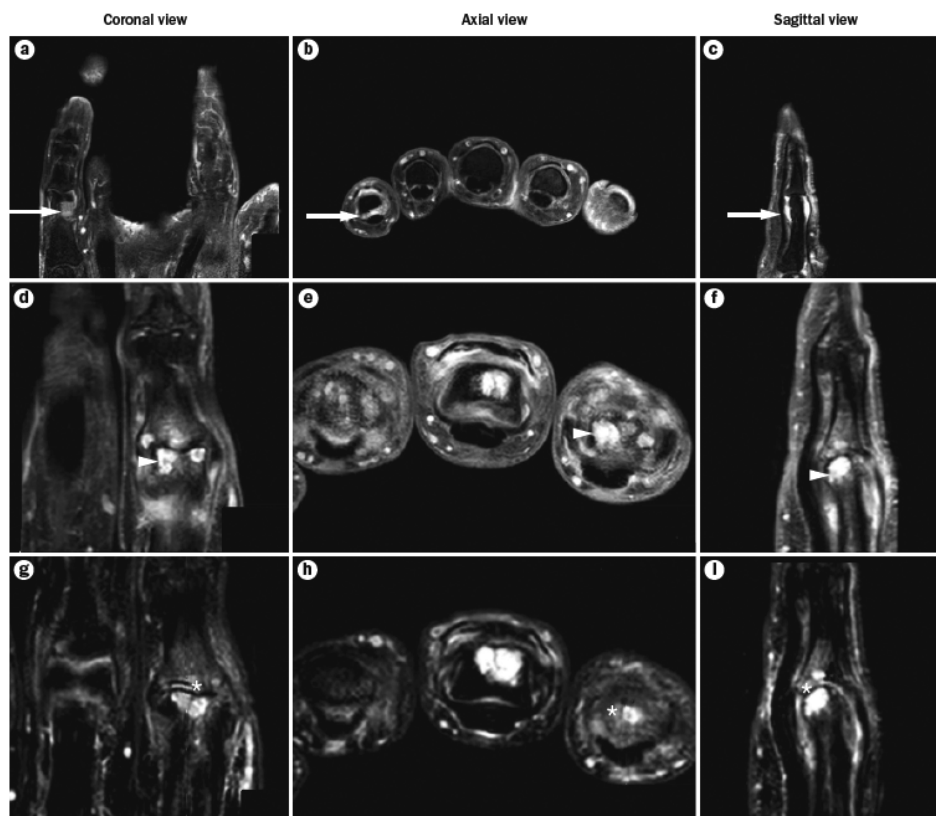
MRI scans showing typical features of hand OA. a-c: T1-weighted image showing synovitis in right 5th PIPJ (arrow). d-f: T1-weighted image showing erosion in right 2nd PIPJ (arrowhead). g-i: T2-weighted image showing bone marrow lesion in right 2nd PIPJ (asterix). Gadolinium was used as contrast agent in images in part a-c and d-f, scanning at 3 teslas occurred in all images. Abbreviations: PIPJ, proximal interphalangeal joint; OA, osteoarthritis.
